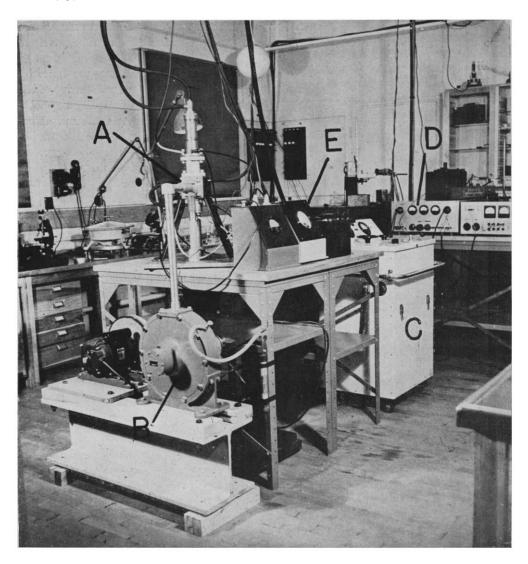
View of the experimental apparatus: A, x-ray tube; B, molecular pump; C, high voltage equipment; D, stabilizing unit; E, high voltage meters.
